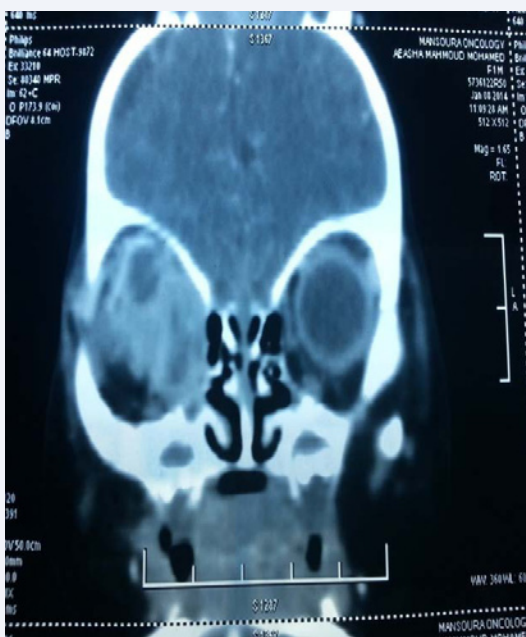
CT orbit (Coronal plane).
